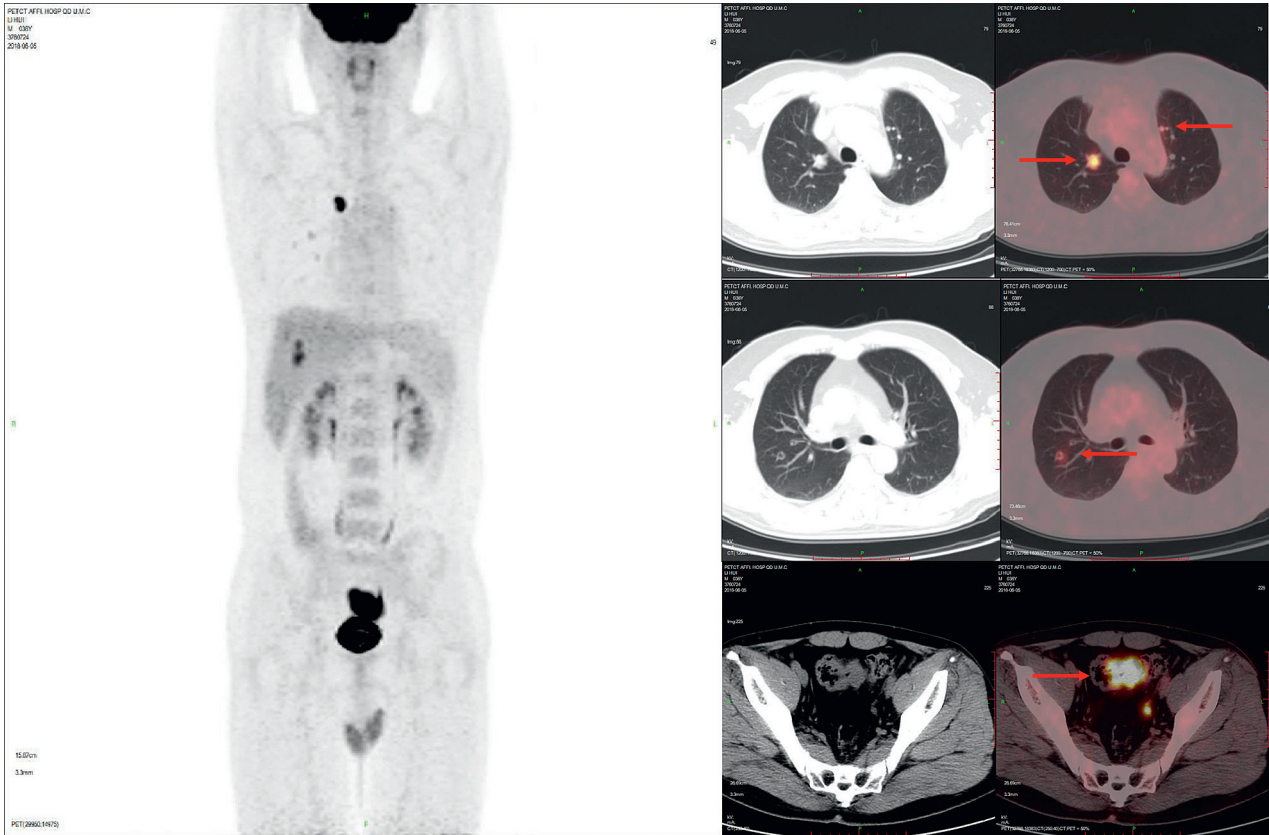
Male, 38 years old, having sigmoid colon cancer (SUVmax, 20.5) and multiple lung metastases (SUVmax, 15.3).
